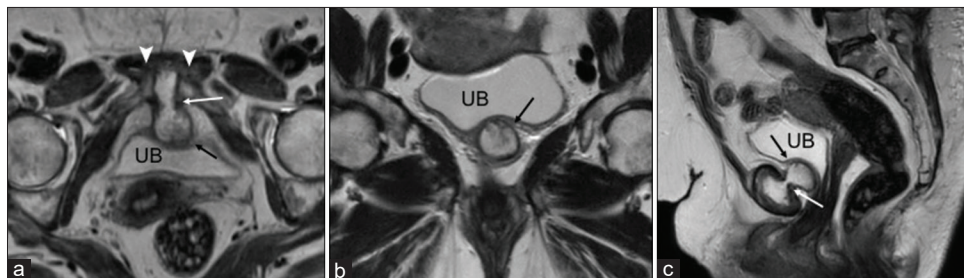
T2-weighted MR images in axial (a), coronal (b), and sagittal (c) planes show a well-defined hyperintense lesion (black arrow) in the space of Retzius in continuity with the symphyseal cartilage with a connecting stalk (white arrow). Note indentation of the bladder neck by the mass on sagittal plane. White arrowheads show pubic diastasis.
